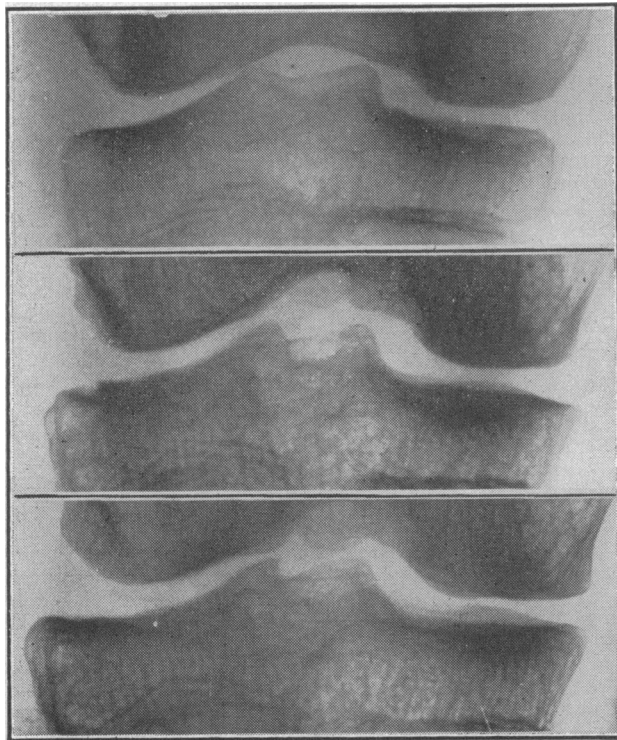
X-ray films showing healing of what had been thought to be an erosion. Top film was taken on January 13, 1953; the middle one on November 20, 1953; and the bottom one on December 29, 1954.
